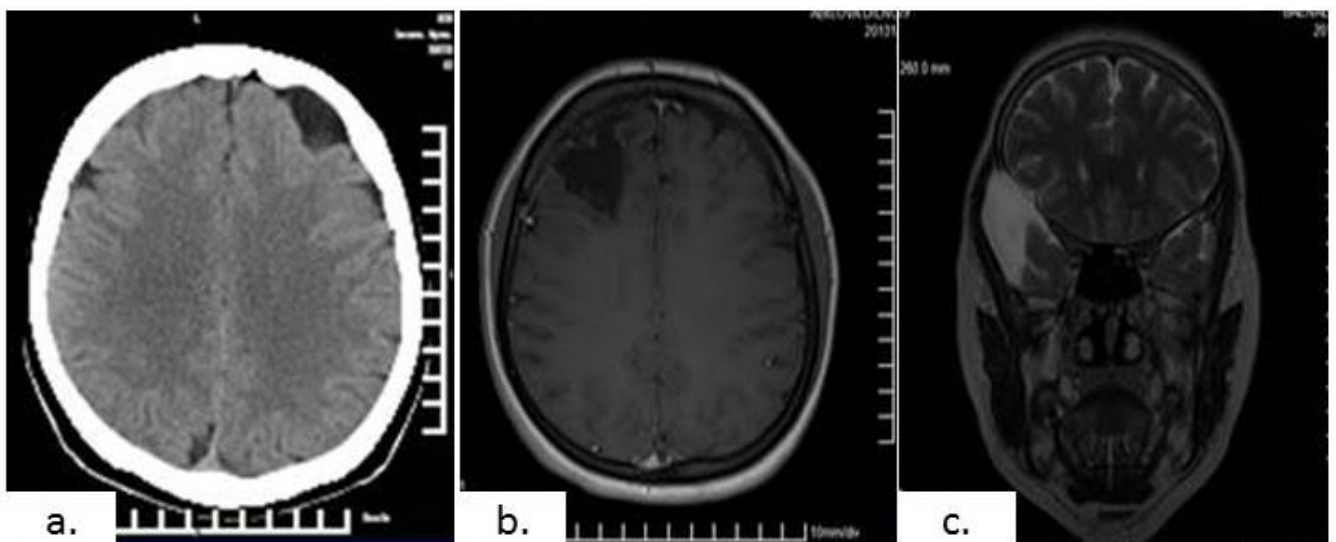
Forms of outcomes of TBI (MRI and CT examples). a) Posttraumatic cystic cerebral arachnoiditis. CT of patient K. Is determined by a small arachnoid cysts in the left frontal region and cystic-adhesive changes of convexital areas of the brain. b) Posttraumatic epilepsy. MRI of patient R. Determined by the seat of epilepsy – posttraumatic cystic-gliar degeneration in the right frontal region of the brain. c) Posttraumatic arachnoidal cyst. MRI of patient B. Is determined by a arachnoid cysts in the right temporal-basal region of the brain
